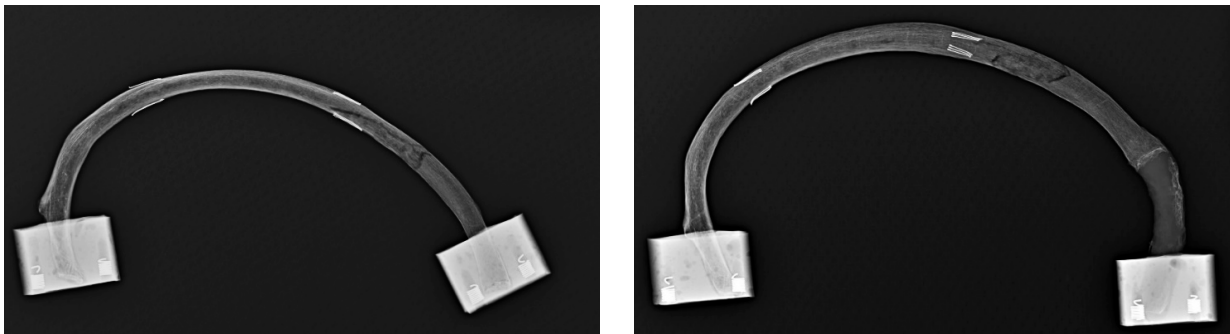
Pair 8 rib (left) and rib+CC (right) post-test x-rays (not to scale)
